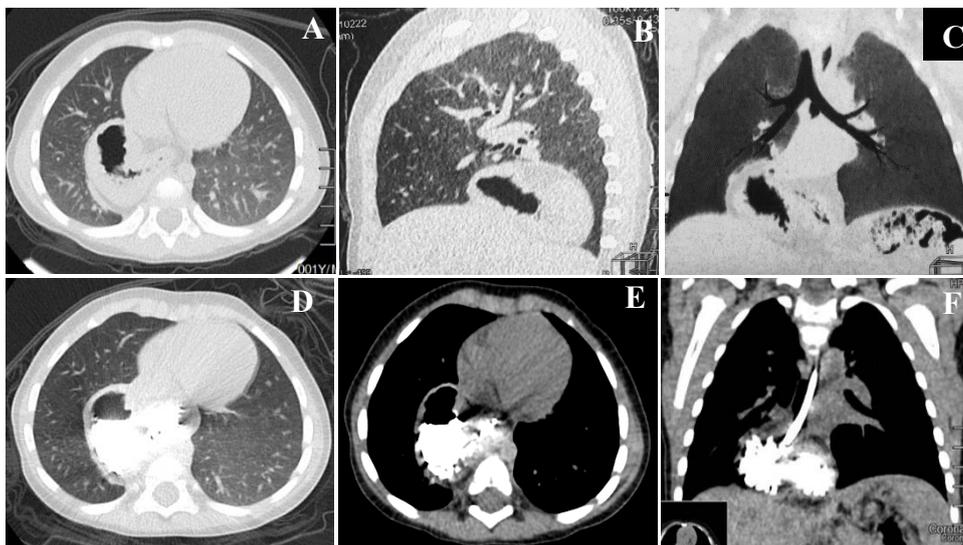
Patient I.M. Computed tomography (the explanation is in the text).
